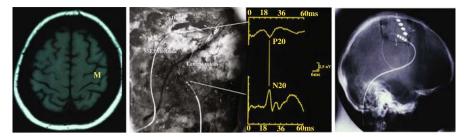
Precentral (Motor) Cortex Stimulation. Left: Precentral (Motor [M]) Cortex on MRI. Center: operative view of extradural space in the central region after 5×5 cm craniotomy: Central sulcus landmark (black line) was drawn on dura at the sites of the reversal N20 (post-central) and P20 (precentral) potentials of intra-operative SSEP, recorded with platine ball electrode. *Right:* Postoperative lateral X-ray radiography of the electrode implanted extradurally, on the right precentral cortex, in a patient with hyperpathic thalamic syndrome in the left side of the body. Pain developed one year after a stroke in the right subcortical posterior parietal area. In this case, PCS gave total and long lasting relief of pain (follow-up 5 years)
